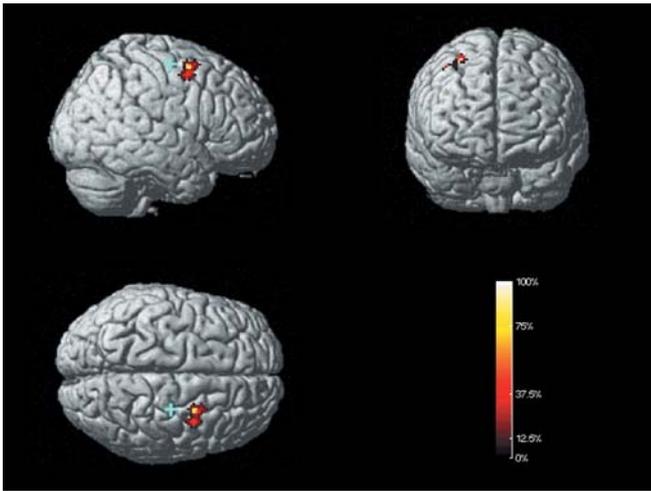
The site of frontal eye field (FEF) stimulation across subjects is represented on this normalized Montreal Neurological Institute (MNI) magnetic resonance imaging (MRI) scan template. Each participant's FEF stimulation site was rendered onto this template with a 1-cm diameter circular region representing the approximate site and volume of activation by the TMS. The hand area of the motor cortex, which was used as a reference point, is depicted by the + sign. The scalp measurements from the hand area of the motor cortex to the FEF, taken from each subject (in millimeters), were used to plot the location of the FEF on this template with respect to the hand area in x , y , and z coordinates. Since the coordinate system of the MNI template is in millimeters, the distances measured on the scalp (also in millimeters) were directly translated on to this template without any scaling or normalization, which may have introduced slight offsets in the averaging. The *brighter intensities* in the frontal cortex represent greater degrees of overlap in the site of stimulation. The maximal region of overlap across the subjects was the cortex located 1.5 cm anterior and 0.3 cm lateral to the motor hand area. The figure was generated using Matlab (MathWorks, Natick, Mass., USA) and some of the functions in SPM99 (Wellcome Department of Cognitive Neurology, UCL, London, UK)
